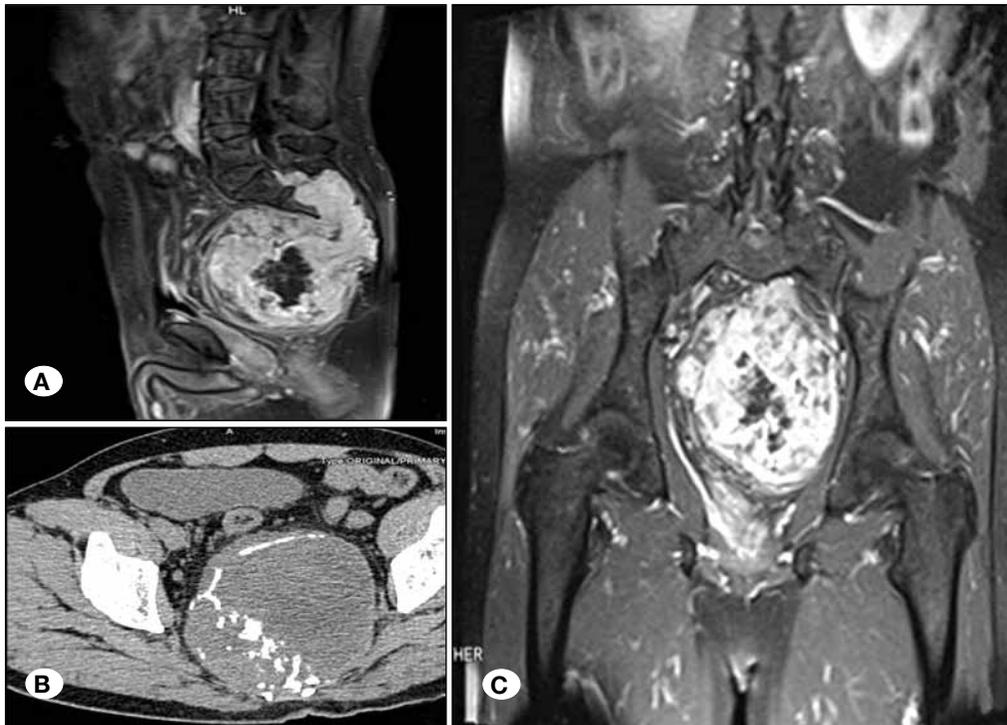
A 71-year-old female complained of urinary and bowel dysfunction for six months. MRI (A, C) and CT (B) showed the giant tumor located at the midline and involving the S1 level. There was some necrosis with a low intensity signal located in the centre of tumor. The tumor was giant cell tumor of bone.
